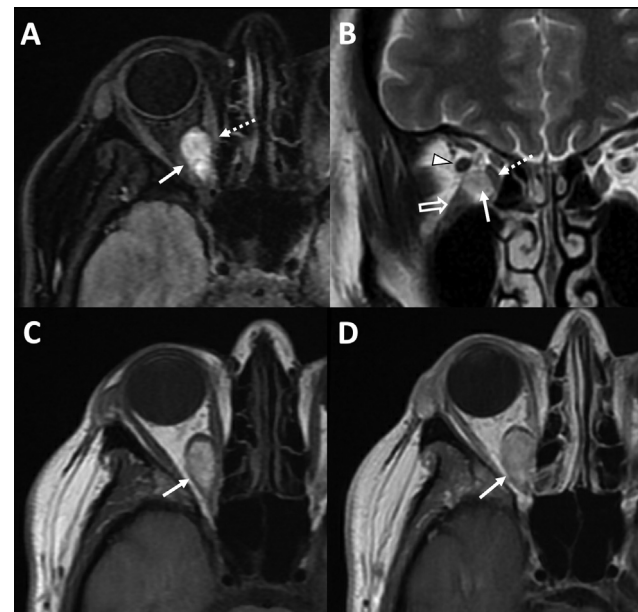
(A) Axial T2 fluid-attenuated inversion recovery (FLAIR), (B) coronal T2-weighted, (C) precontrast, and (D) postcontrast axial T1-weighted magnetic resonance imaging (MRI) of the brain at the level of orbit after intravenous injection of 20 mL of gadoteridol (ProHance; Bracco). There is a 2.0 × 1.0 cm sized well-defined T1, T2, and FLAIR hyperintense, nonenhancing, right orbital intraconal lesion (solid white arrows in A–D), abutting the right medial (dashed white arrow in A and B) and inferior rectus muscle (open white arrow in B) and the right optic nerve (white arrowhead in B). Posteriorly, the hematoma is reaching up to the orbital apex. Bilateral orbital globes and left retro-orbital space were unremarkable.
